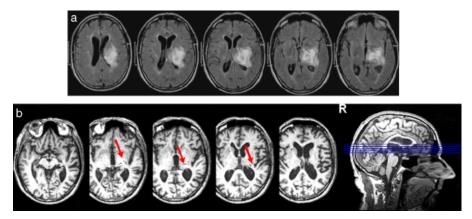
a. T2 fluid-attenuated inversion recovery (FLAIR) axial slices. b. Lesion location. The patient had a single unilateral cerebrovascular incident of the right thalamus and the adjacent corticospinal tract of the internal capsule 14 months prior to study entry.
